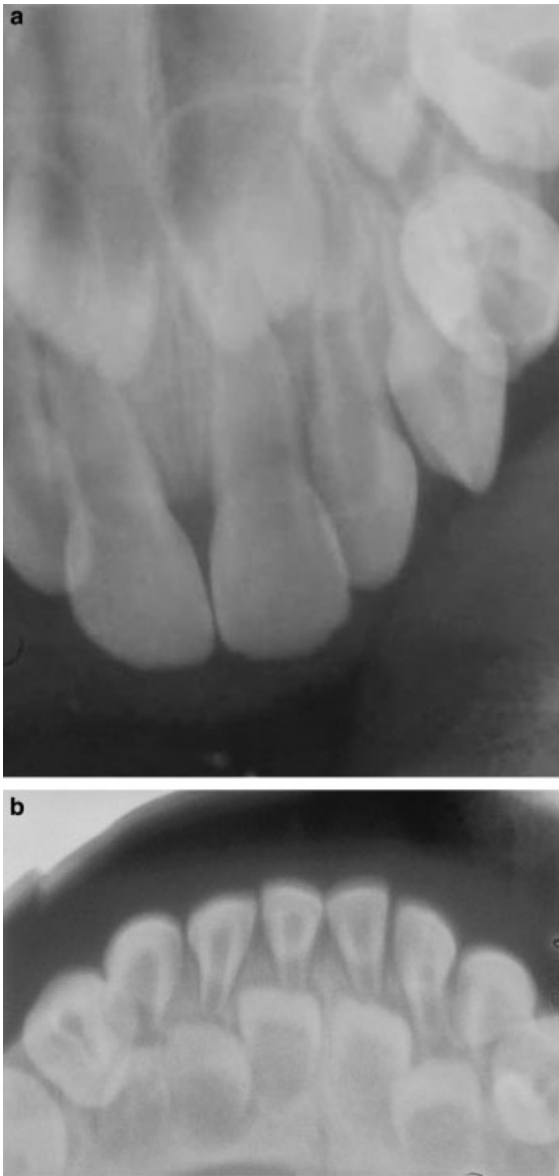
Radiographs revealed clear pulp chambers and root canals with no calcifications in the maxillary (a) or the mandibular incisors (b)
